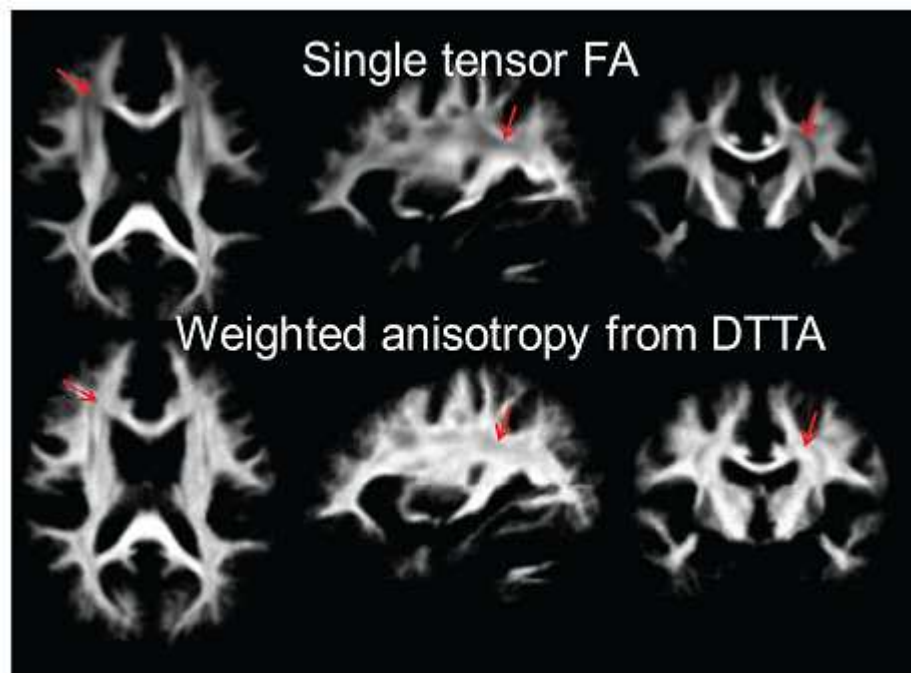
Single tensor FA (upper panels) and weighted anisotropy from DTTA (lower panels) averaged from low b DWI from 10 subjects. The red arrows point to some typical regions with apparently lower single tensor FA due to fiber crossing. Compared to single tensor FA, weighted anisotropy from DTTA provides unbiased measure of WM integrity at the CFR in the entire brain.
